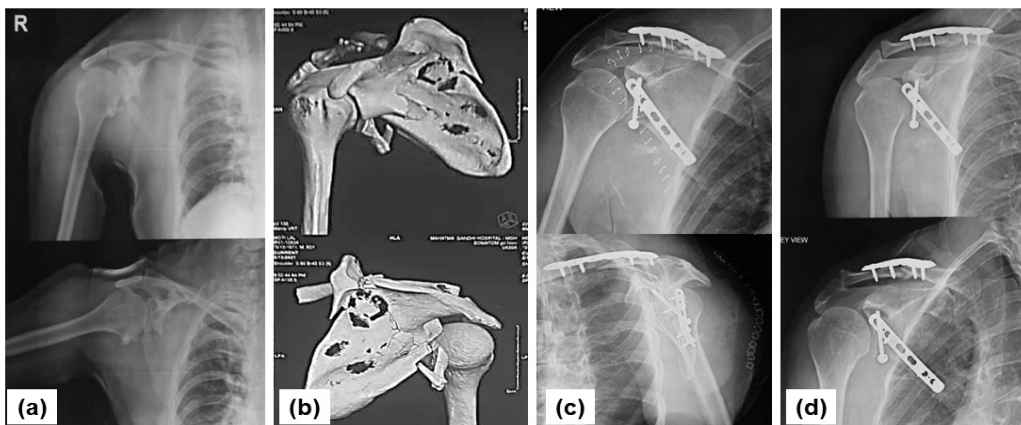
Preoperative X-ray (a); Preoperative CT Scan (b); Postoperative X-ray (c) and Follow-up X-ray (d).
